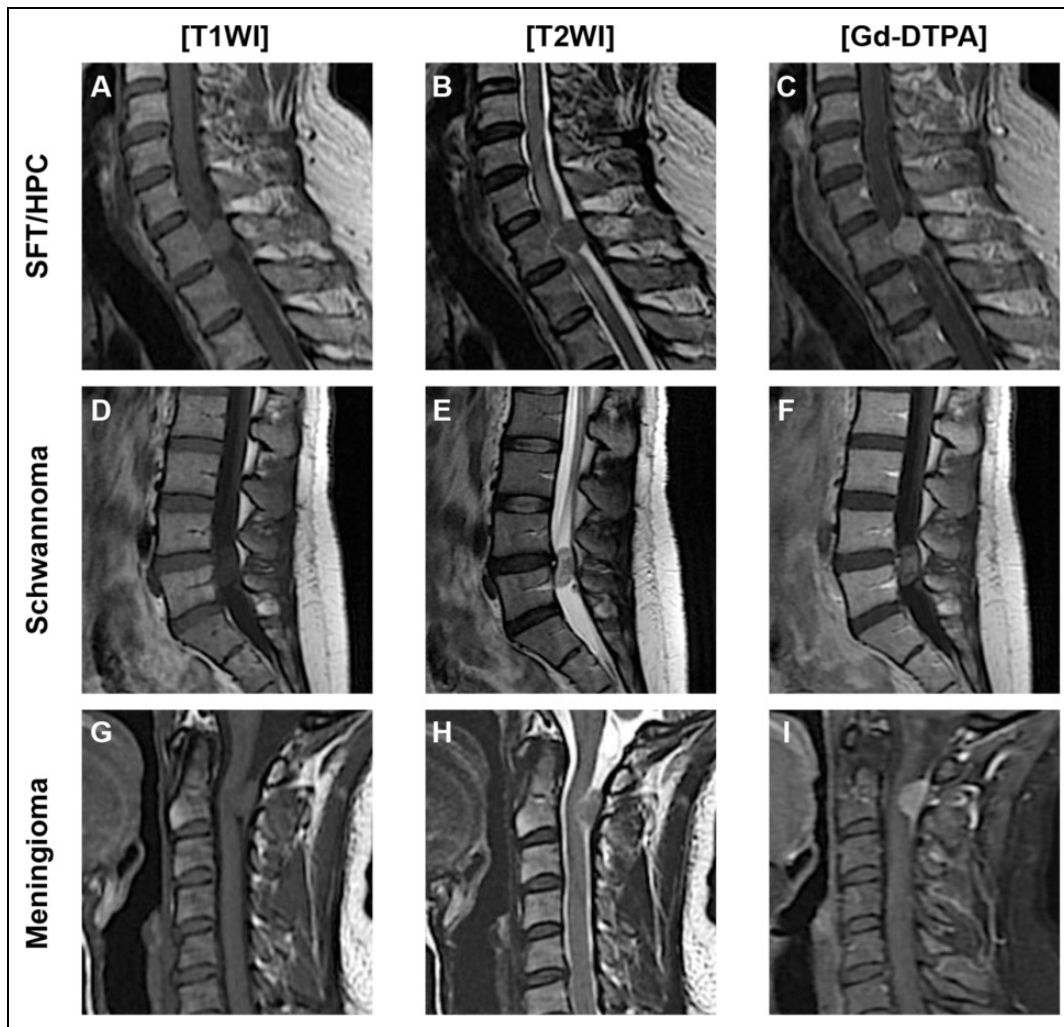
Representative sagittal MRI findings of patient with intraspinal SFT/HPC, schwannoma, and meningioma. SFT/HPC exhibited isointensity on both T1- (A) and T2-weighted images (B). T1-weighted MRI after injection of Gd-DTPA revealed a uniformizing enhancement pattern, the lack of the dural tail sign, and irregularities in tumor margins (C). By contrast, schwannoma showed low intensity on T1- (D), isointensity on T2-weighted images (E), and heterogeneous Gd-DTPA enhancement pattern (F). Meningioma showed isointensity on both T1- (G) and T2-weighted images (H), uniformizing enhancement pattern and dural tail sign (I). Edges of tumor were well defined in both schwannoma and meningioma. Abbreviations: SFT/HPC, solitary fibrous tumor/hemangiopericytoma; T1WI, T1-weighted image; T2WI, T2-weighted image; Gd-DTPA, gadolinium diethylenetriamine pentaacetic acid.
